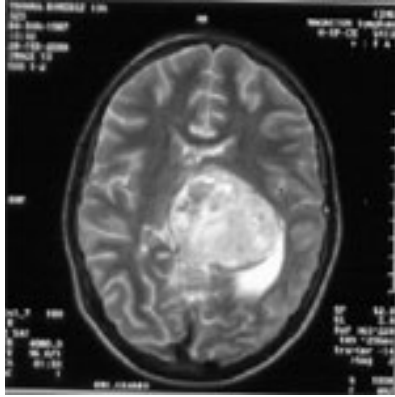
T2-weighted MRI of a Giant cell glioblastoma of third ventricle with periphery necrosis and mass effect.
